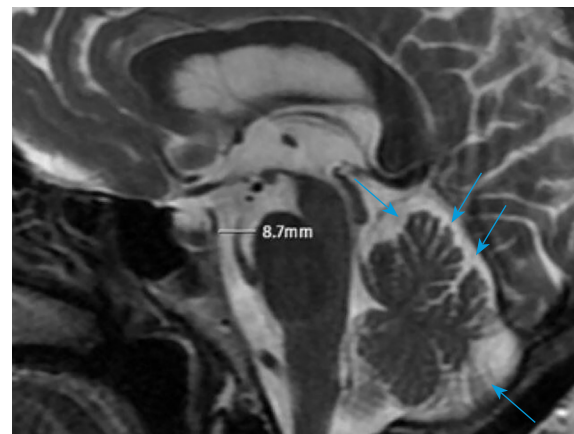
Magnetic resonance imaging performed 6 months earlier showed that the cerebellar hemispheres were atrophic and adjacent subarachnoid spaces were extensively dilated (arrows).
